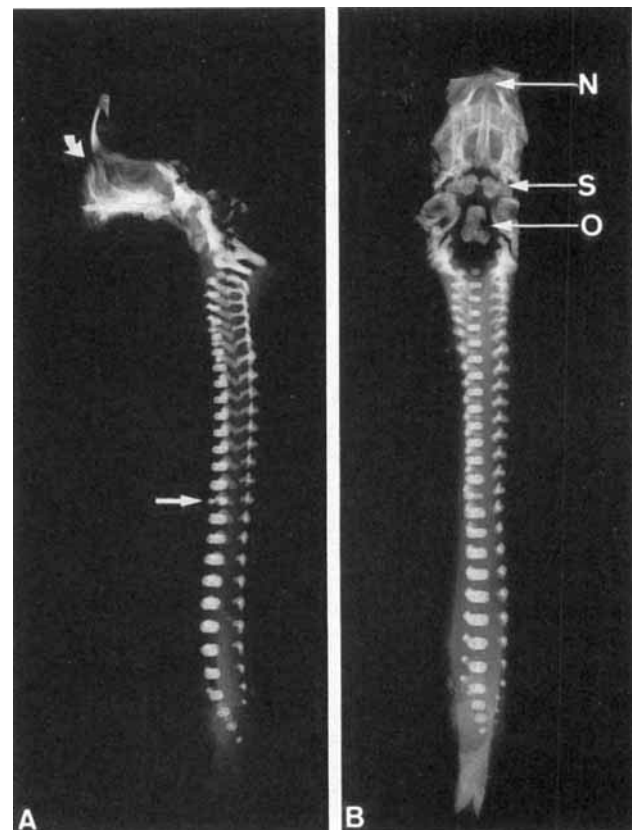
Radiographs of axial skeleton of human fetus with trisomy 18, 18 weeks of gestational age. A: Lateral view. Note agenesis of nasal bones in the field indicated (curved arrow), and malformation of eighth thoracic vertebral body (straight arrow). B: Frontal view. Note agenesis of nasal bones in developmental field N, bilateral ossification centers of the postsphenoid bone located in field S, and unilateral notching of the basilar part of the occipital bone (O) ($\times 0.9$).
